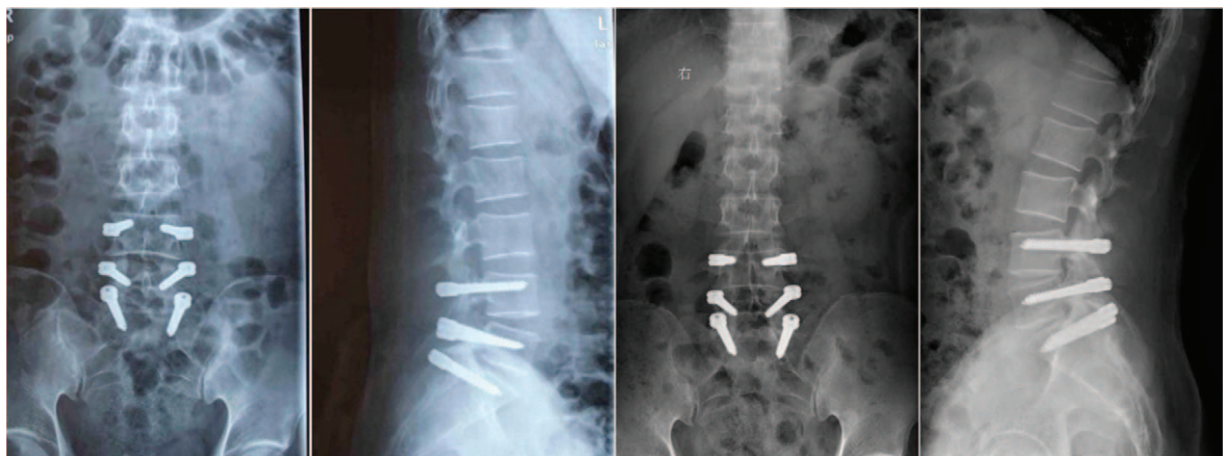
(A, B) Postoperative radiograph; (C, D) radiograph at 4 years of follow-up.
